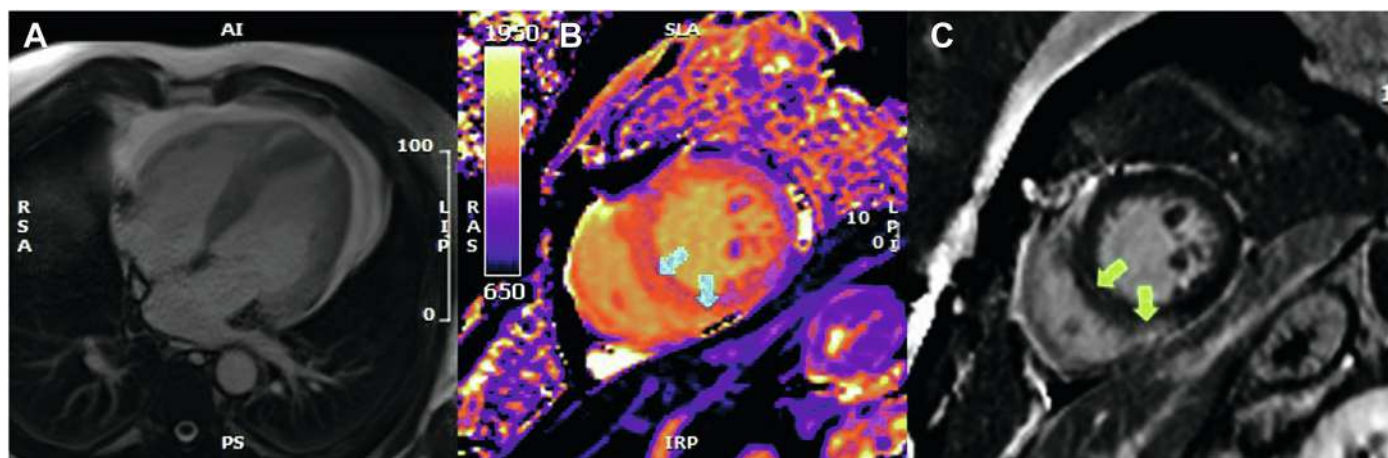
Cardiac magnetic resonance imaging (CMRI) findings in a patient with mRNA vaccine-associated myocarditis. Patient presented to hospital 2 days after the second COVID-19 mRNA vaccine with chest pain. Troponin T was elevated at 105 ng/L (normal < 15 ng/L). A, CMRI demonstrated normal left ventricular function. B, T1 mapping suggested myocardial edema in the inferoseptum and inferior segments (arrows) with corresponding nonischemic scar on late gadolinium enhancement imaging (C, arrows). (From Crosier R, Kafil TS, Paterson DI. *Imaging for Cardiovascular Complications of COVID-19: Cardiac Manifestations in Context*. *Can J Cardiol*. 2023;39:779–792. Fig. 7.)
